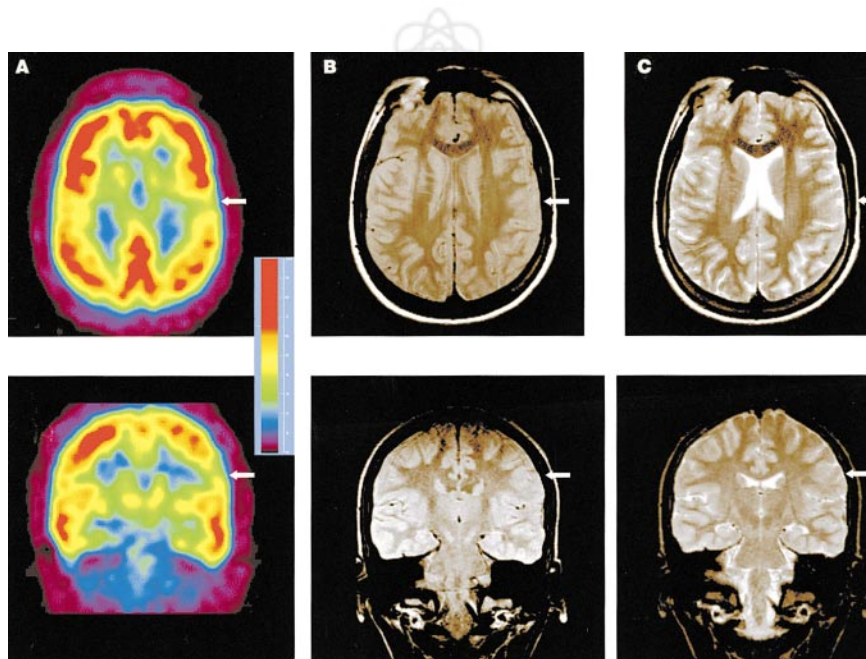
Axial and coronal FDG PET (A), proton density-weighted MRI (B), and T2-weighted MRI (C) images from 13-y-old girl with medically refractory extratemporal seizures. MRI findings were initially reported as normal, whereas FDG PET showed region of focal hypometabolism around left inferior rolandic area (arrows). Review of MR images showed small region of cortical signal change with blurring of gray matter–white matter junction corresponding to region of PET hypometabolism, consistent with focal cortical dysplasia.
